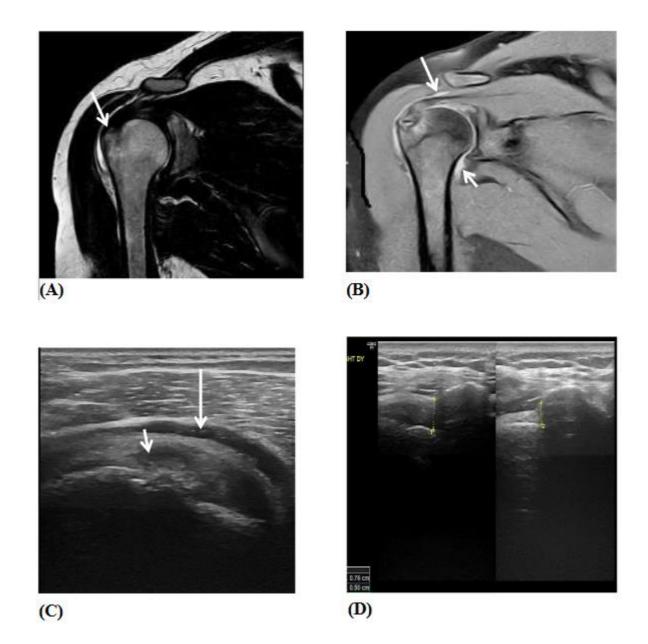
A MRI coronal T2 WI: intrasubstance bright signal at the supraspinatus tendon (arrow) yet with preserved fiber continuity. B MRI coronal T2 PD WI: fluid signal at the subacromial subdeltoid bursa (arrow) and minimal joint effusion (short arrow). C Static US shows swollen supraspinatous tendon with reduced echogenicity yet no tears detected (short arrow) and hypoechoic fluid distending the subacromial subdetoid bursa (tall arrow).D narrowed subacromial tunnel in dynamic US that was increased in stress position.
